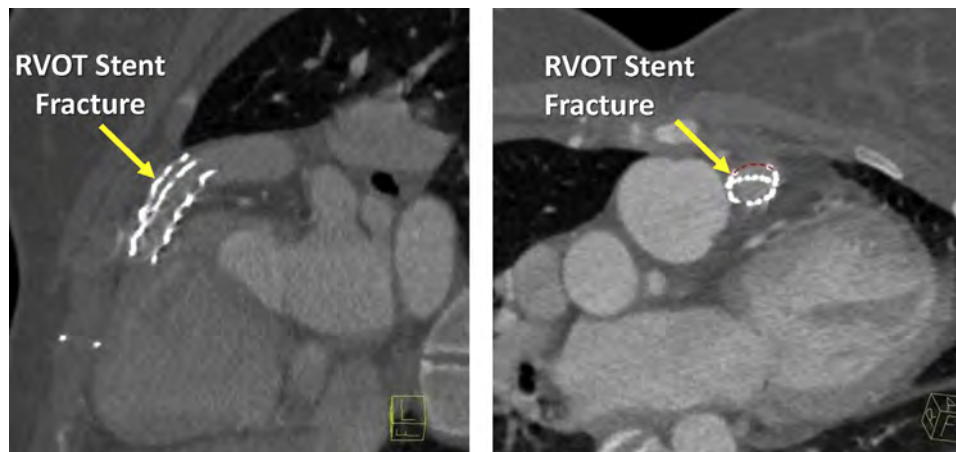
Value of CT angiography in evaluating the mechanism of significant PR after TPVR. Longitudinal and cross-sectional images of a fractured RVOT stent are depicted, showing discontinuity of the stent circumference (*red dotted line*) and collapse of the fractured stent into the vessel lumen.
